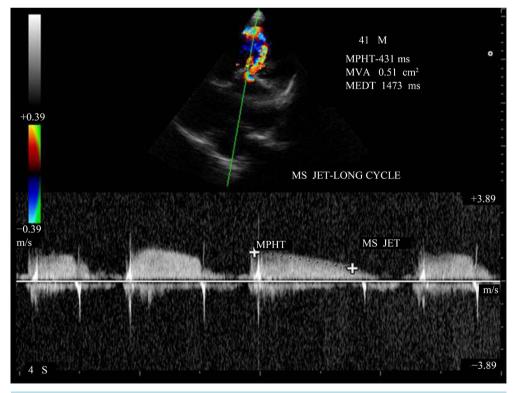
CW doppler showing the MS jet-long cycle pressure half-time.
